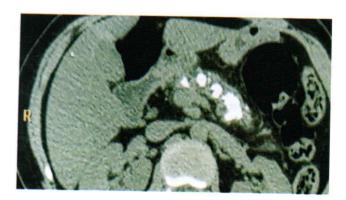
Stones are seen in the MPD on limited CT
